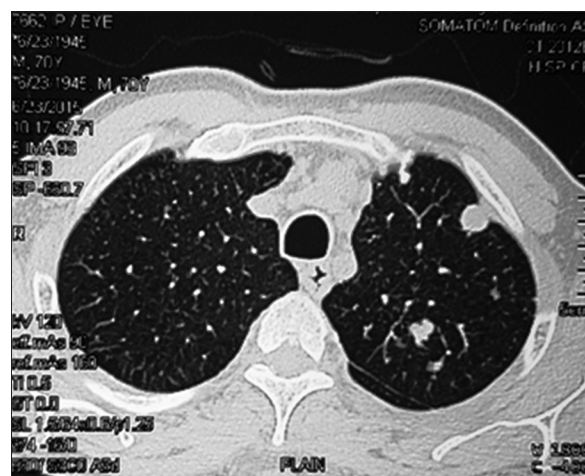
Computed tomography of the chest showing multiple lung hilar and parenchymal lesions suggestive of metastases
